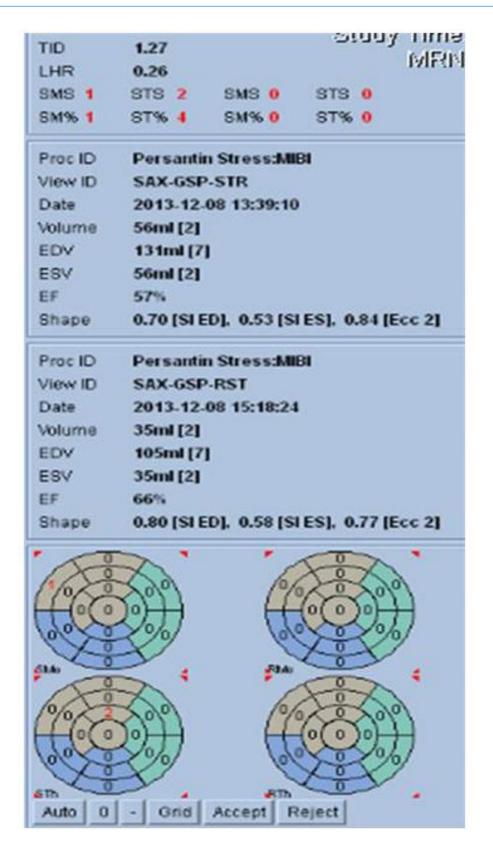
SPECT (Figure 1a): Stress induced ischemia (Arrows): anterior (white), apex (yellow) and antero-lateral wall (Green) shown on polar map (Figure 1b).
